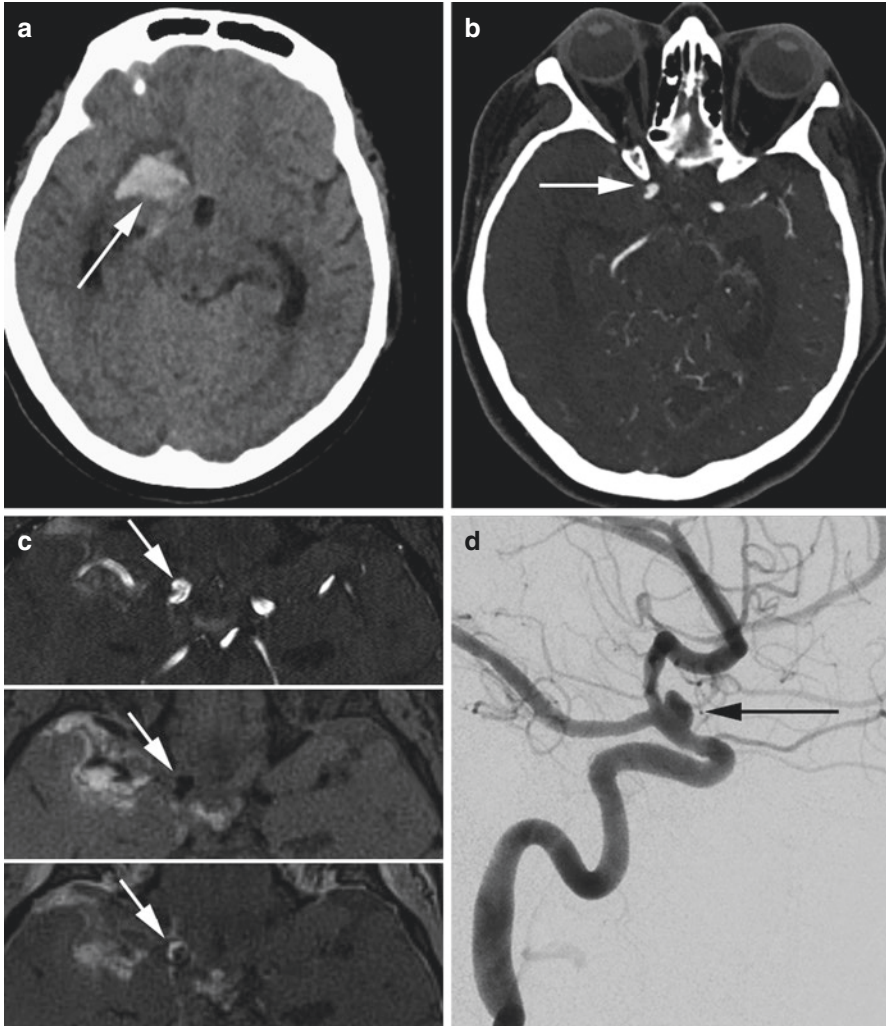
Dorsal variant internal carotid artery pseudoaneurysm. Patient with intraparenchymal and subarachnoid hemorrhage on initial CT scan (a). Axial CTA (b) shows a right ICA ophthalmic segment blister aneurysm (arrow). Vessel wall imaging was performed with the aneurysm (arrow) on time-of-flight (c, top), flow suppressed T1 precontrast (c, middle), and with vessel wall enhancement flow suppressed T1 postcontrast (c, bottom). DSA (d) confirms a dorsal variant ICA pseudoaneurysm (arrow)
